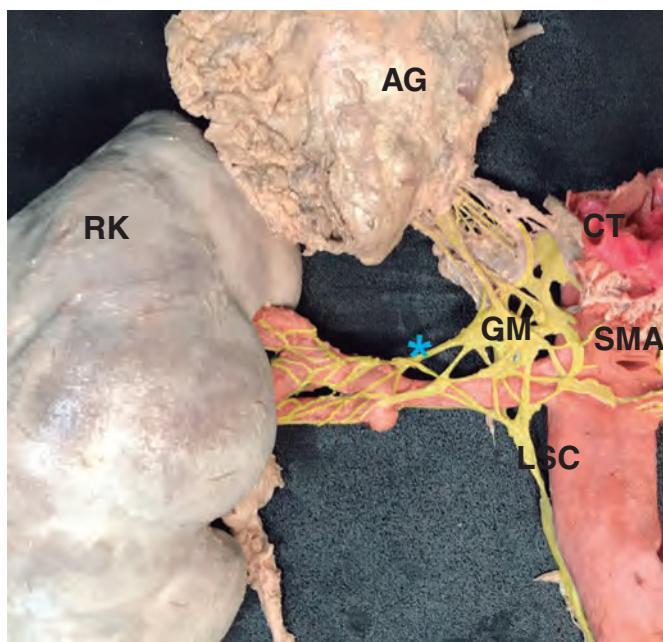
Detail of renal sympathetic innervation. Renal nerves are usually arranged in large bundles and only form a true plexus when they are close to entering the kidney. Some nerves bypass the main renal artery and join distally to the different arterial divisions of the main renal artery (late arrival nerves). In this case, a late arrival nerve is seen joining the proximal third of the anterior division of the main renal artery (blue asterisk). It can also be seen how the proximal main renal artery is occupied by fused ganglia of the solar plexus (GM), and by the lumbar sympathetic chain (LSC). Both provide innervation to the kidneys, but also to other abdominal and pelvic organs, which can be accidentally denervated if the proximal third of the main renal artery is treated. The image also shows that the maximum proximity of nerve fibers to the arterial wall mainly occurs at branch level, but also at main trunk level. This is the target area of treatment, always avoiding the application of radiofrequency at renal pelvis level. AG, adrenal gland; CT, celiac trunk; GM, ganglionic mass made up of the aortorenal and celiac ganglia; LSC, lumbar sympathetic chain; RK, right kidney; SMA, superior mesenteric artery; blue asterisk, late arrival nerve. In red, arterial structures. In yellow, nervous tissue.
